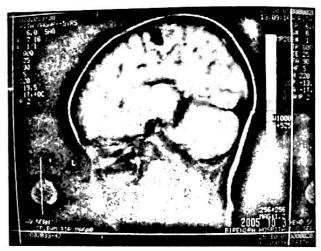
Post operative MRI scan.
